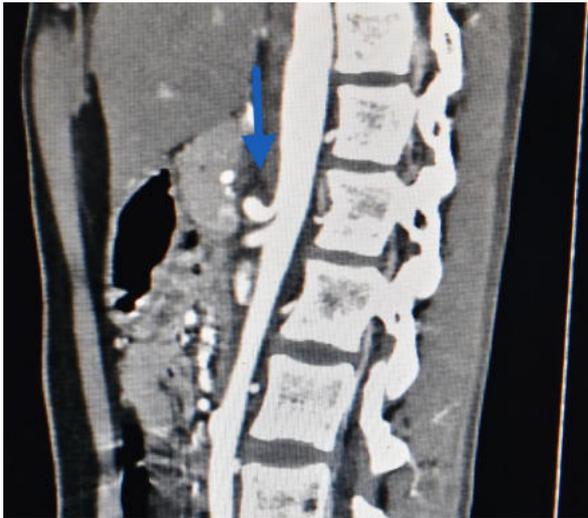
CT Angiogram image showing “Hook sign”
